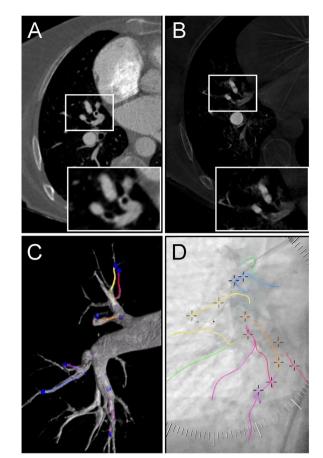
Balloon pulmonary angioplasty procedural planning using cone beam CT-pulmonary angiography. 62-year-old woman with confirmed chronic thromboembolic pulmonary hypertension (CTEPH) undergoing her first balloon pulmonary angioplasty (BPA) session. (A-B) Chronic thromboembolic lesion (band) affecting the segmental medial branch of the middle lobe, is not fully characterizable using single-energy CT pulmonary angiography (CTPA) (A), but ultimately seen using cone beam CT-pulmonary angiography (CBCT-PA) (B), CBCTPA has the potential to better characterize distal (segmental and subsegmental) chronic thromboembolic lesions compared to CTPA and digital subtraction pulmonary angiography. (C) Three-dimensional reconstruction of CBCTPA was performed before starting BPA. This allows procedural planning by marking all lesions to be treated (crosses in D) and a road map (colored lines), which can be superimposed on the live fluoroscopic image during the procedure, as demonstrated in (D).
